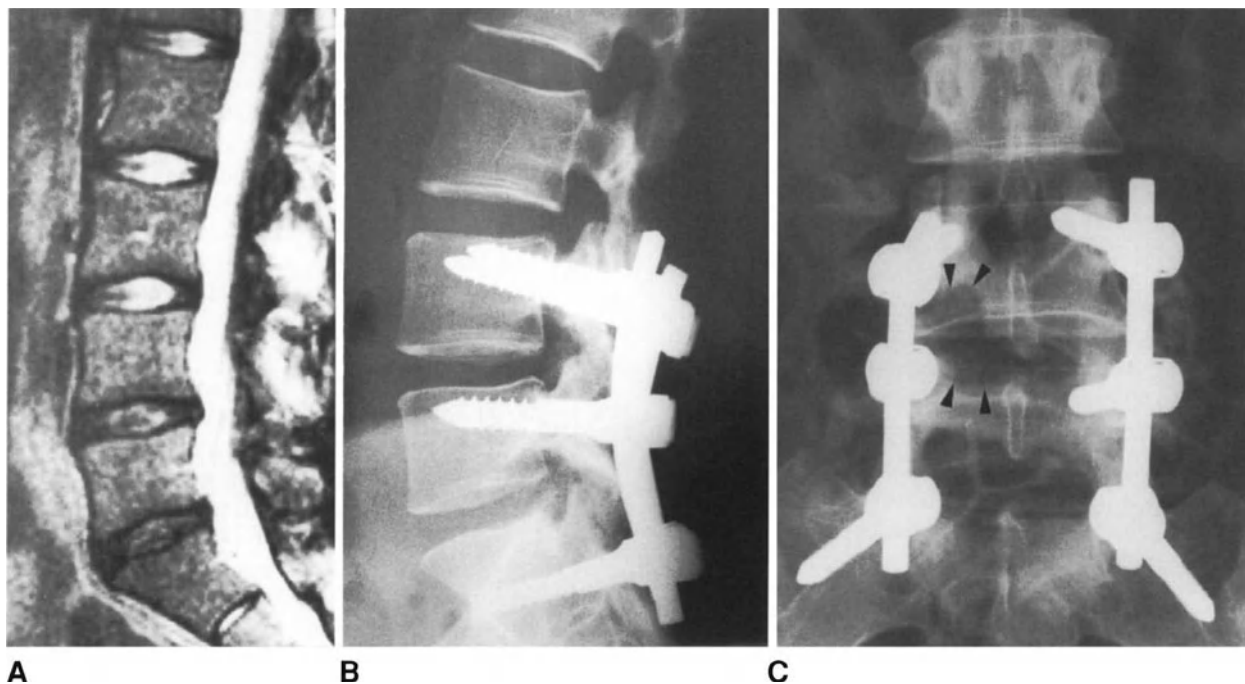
Thirty-nine-year-old female with marked low back pain and mild radicular pain on the right side. Spin-echo T2-weighted sagittal MR scan (A) showing a small contained herniation at L4-L5 level and disc degeneration at L4-L5 and L5-S1 levels. An instrumented posterolateral fusion at L4-L5 levels (B) and (C) was performed along with laminotomy and discectomy on the right (arrowheads).
